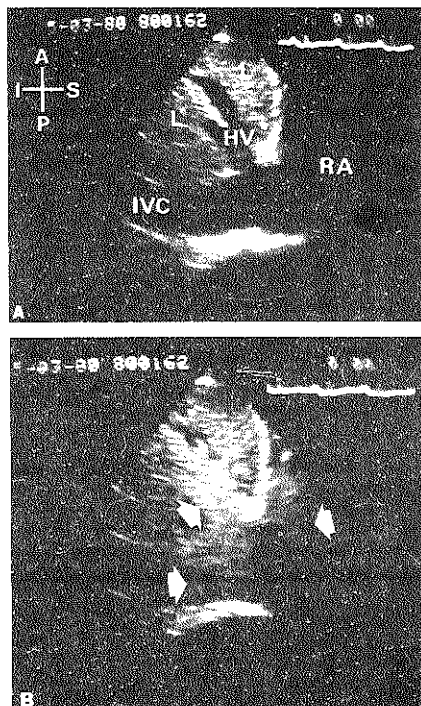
Stop-frame photographs from a subcostal two-dimensional echocardiographic study of the inferior vena cava (IVC) and right atrium (RA) before (A) and immediately after (B) upper extremity injection of 5% dextrose in water. The IVC and hepatic vein (HV) fill with contrast (arrows) in this patient with tricuspid regurgitation later proved by intraoperative right atrial palpation. L = liver; A = anterior; P = posterior; I = inferior; S = superior.
